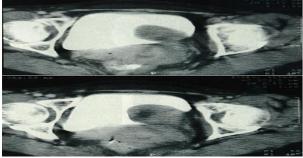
URO –CT scan: tissular processus in the trigone of bladder, with intra and extra compenent. développement endo et extra-vesical.
